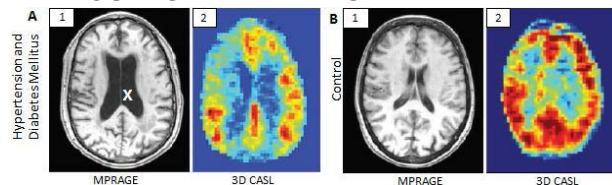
Ventricular enlargement (x), volume loss (A1) and decreased perfusion (A2, blue) in hypertension and diabetes mellitus. Normal volume (B1) and perfusion (B2). Abbreviations: 3D CASL, three-dimensional continuous arterial spin labeling; MPRAGE, T1-weighted magnetization-prepared rapid acquisition with gradient echography (Novak, 2010).
